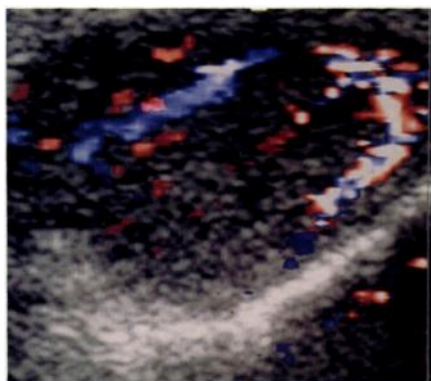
42-year-old man with history of non-Hodgkin's lymphoma. Longitudinal color Doppler sonogram shows generalized diminished echogenicity and marked hyperemia within smoothly contoured right testis. The application of color Doppler sonography helps to make this abnormality more conspicuous.
